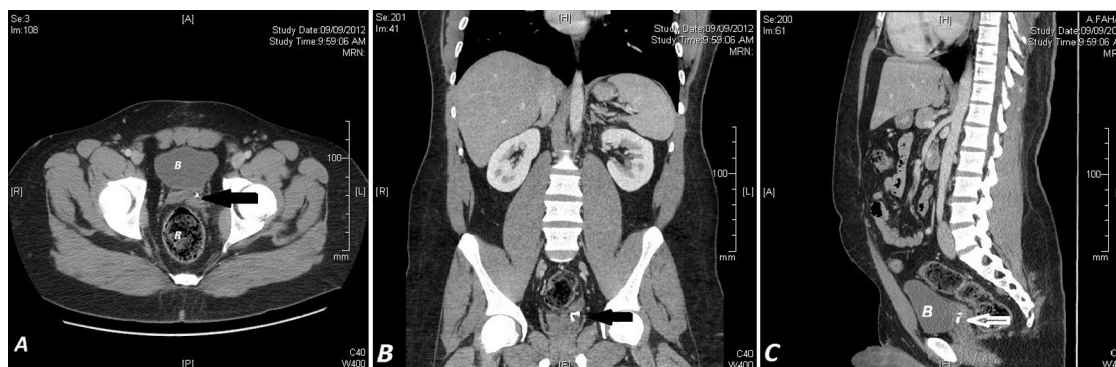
Follow-up CT scan of abdomen and pelvis one year post-operatively showing surgical clips (arrow) at the site of left SV with no evidence of local recurrence or distant metastasis. Bladder (B) and rectum (R).
